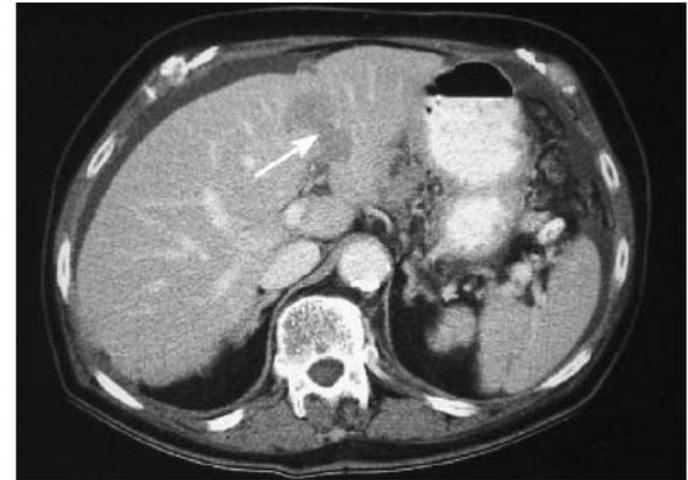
Contrast-enhanced CT demonstrating a metastatic surface implant in the intersegmental fissure of the liver (arrow).
